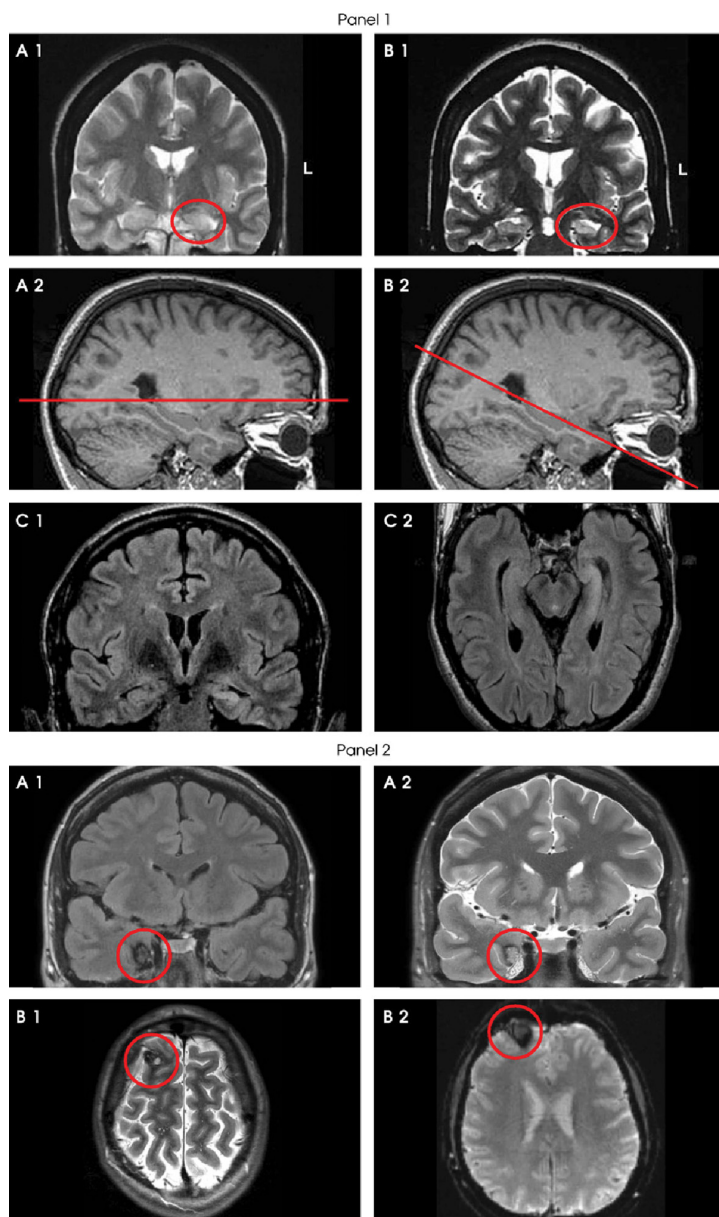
Magnetic resonance imaging in epilepsy. Panel 1: A1, Ammons horn sclerosis left, standard coronal angulation; A2, standard coronal angulation; B1, Ammons horn sclerosis (syn.: mesial temporal sclerosis) left, coronal temporal angulation; B2, coronal temporal angulation; C1, flair sequence coronal and axial, temporal angulation. Panel 2: Cavernoma; A1, mesio-temporal right, flair sequence; A2, T2-weighted; B1, frontal right, T2-weighted; B2, T2*-weighted (pronounced effect of old blood)
